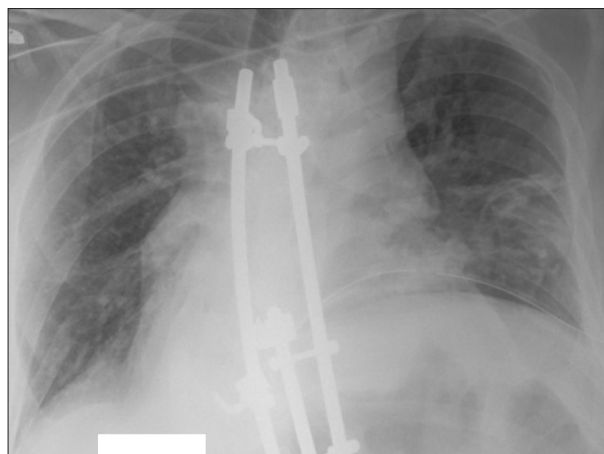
Chest x-ray with chest tube.
